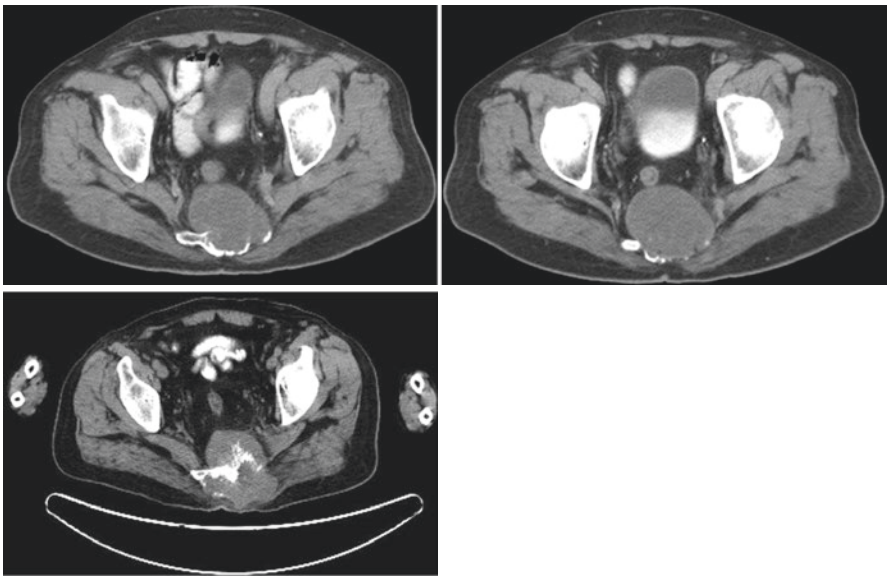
Sacral chordoma. CT findings show destruction of sacrum with soft tissue lesion
